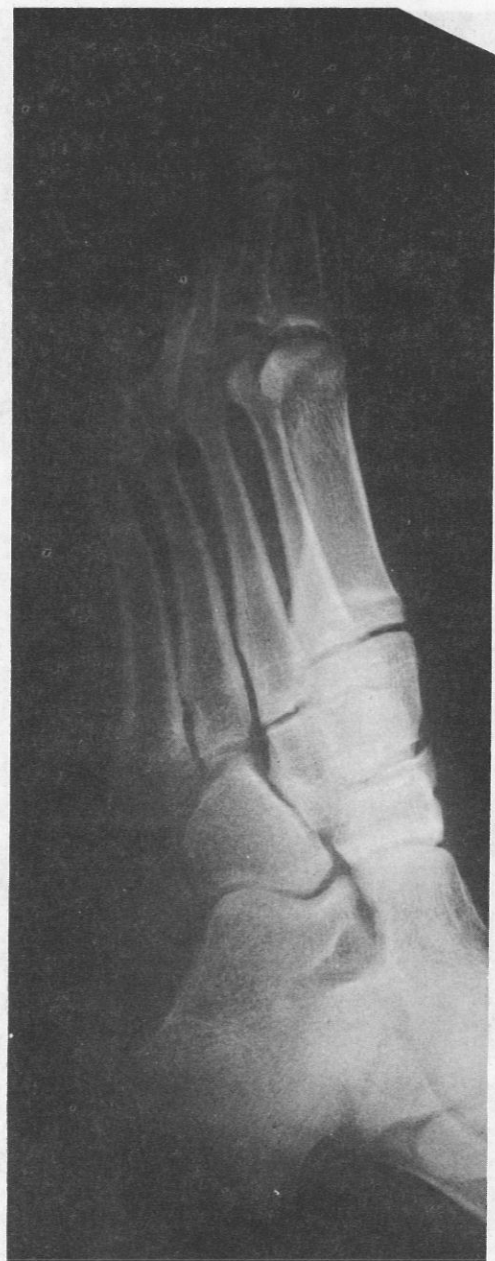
A and B.—AP and oblique X-ray studies reveal fracture at the base of the first metatarsal bone.
